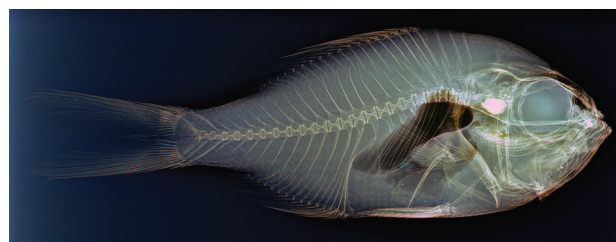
Colored multiexposure HDR image of a red snapper. The image was generated from source 140-, 110-, and 80-keV radiographic images using dedicated HDR postprocessing.
